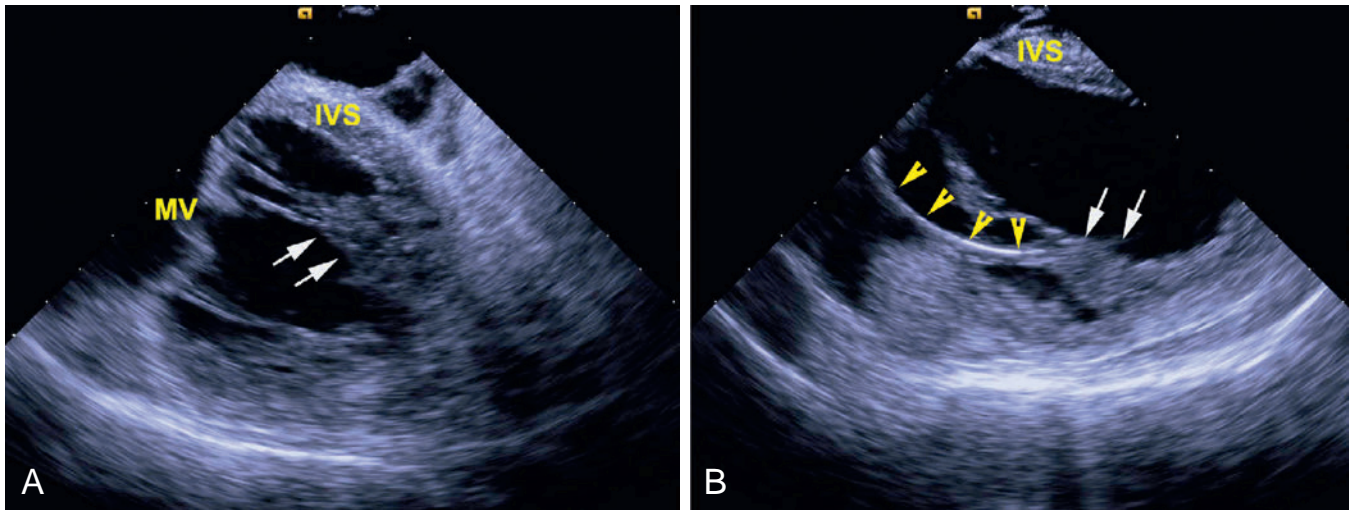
Intracardiac Echocardiography (ICE) for Ablation of Arrhythmias Rising From Left Papillary Muscles. The ICE transducer is positioned in the right ventricle, across the tricuspid valve, abutting the interventricular septum (IVS). (A) The left posteromedial papillary muscle is visualized (white arrows). (B) The left anterolateral papillary muscle is visualized (white arrows) as well as the ablation catheters (yellow arrowheads) which was advanced across the mitral valve (via the atrial transseptal approach). ICE allows confirmation of catheter contact with the anterolateral muscles. MV, Mitral valve.
